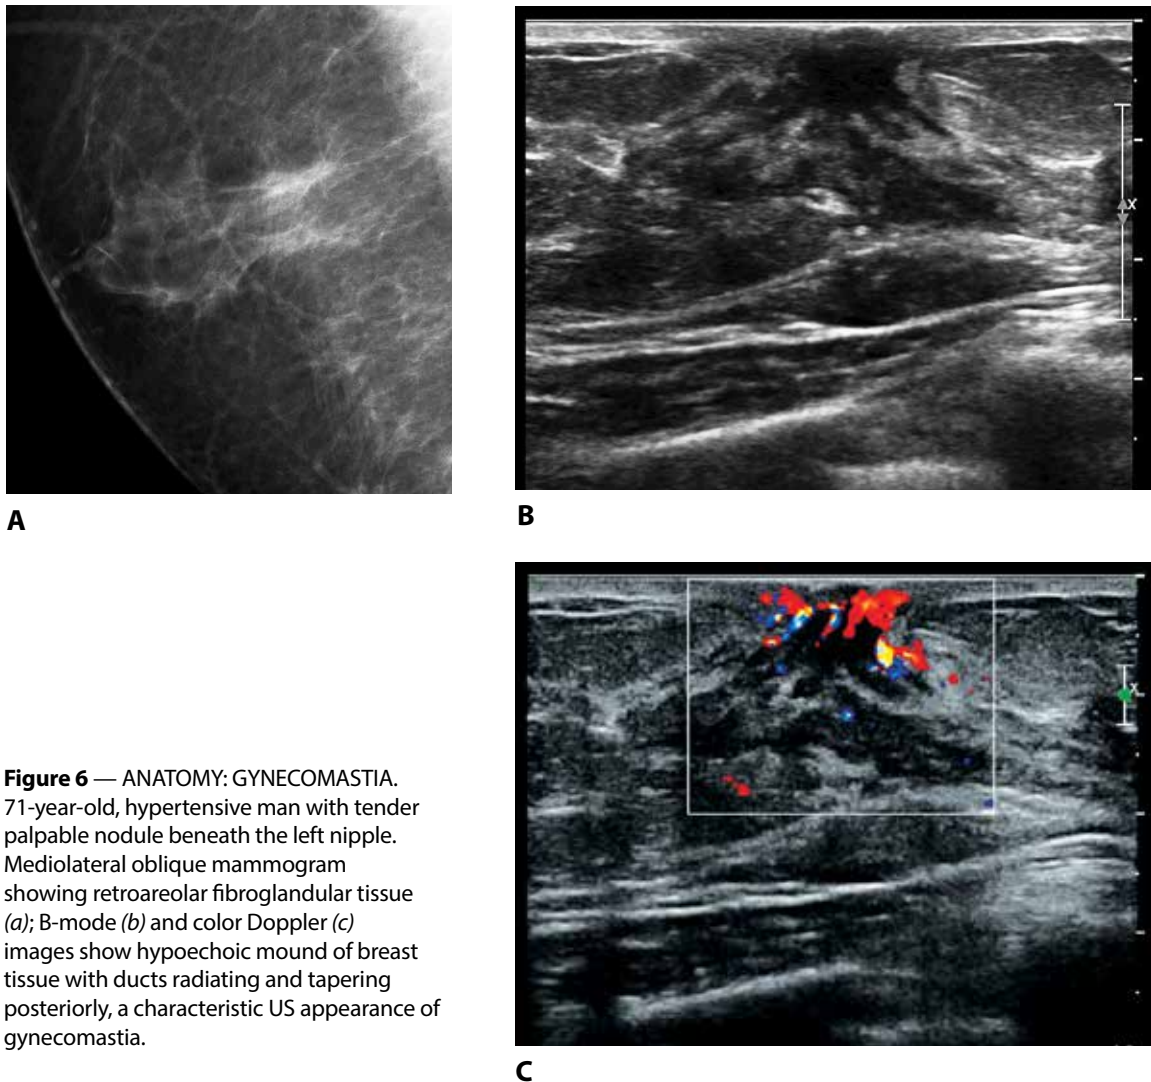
ANATOMY: GYNECOMASTIA. 71-year-old, hypertensive man with tender palpable nodule beneath the left nipple. Mediolateral oblique mammogram showing retroareolar fibroglandular tissue (*a*); B-mode (*b*) and color Doppler (*c*) images show hypoechoic mound of breast tissue with ducts radiating and tapering posteriorly, a characteristic US appearance of gynecomastia.
